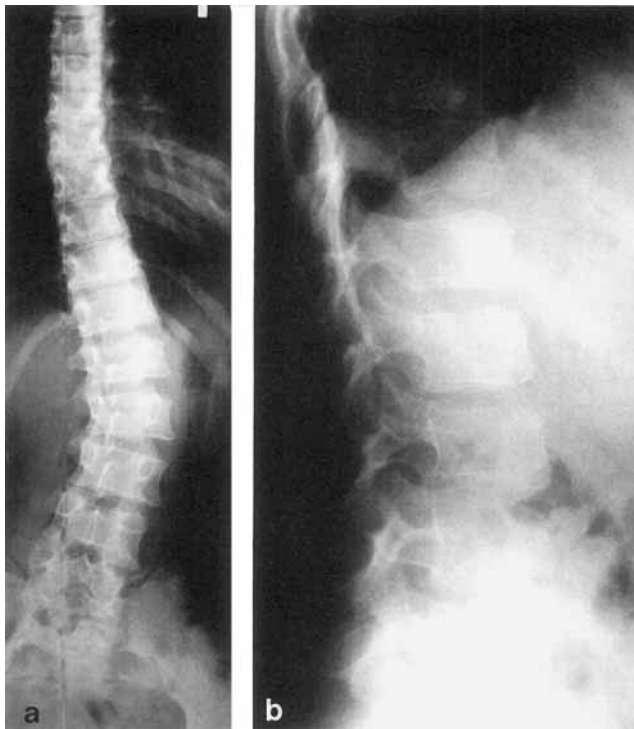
a: Patient 1: age  $9\frac{1}{2}$  years. AP dorsolumbar spine film. Dorsolumbar levoscoliosis with normal vertebral body height. b: Lateral lumbar spine radiograph. Age  $7\frac{1}{2}$  years: normal vertebral height. Mild anterior “humping” of superior and inferior vertebral body end plates of lower dorsal and upper lumbar vertebrae.
